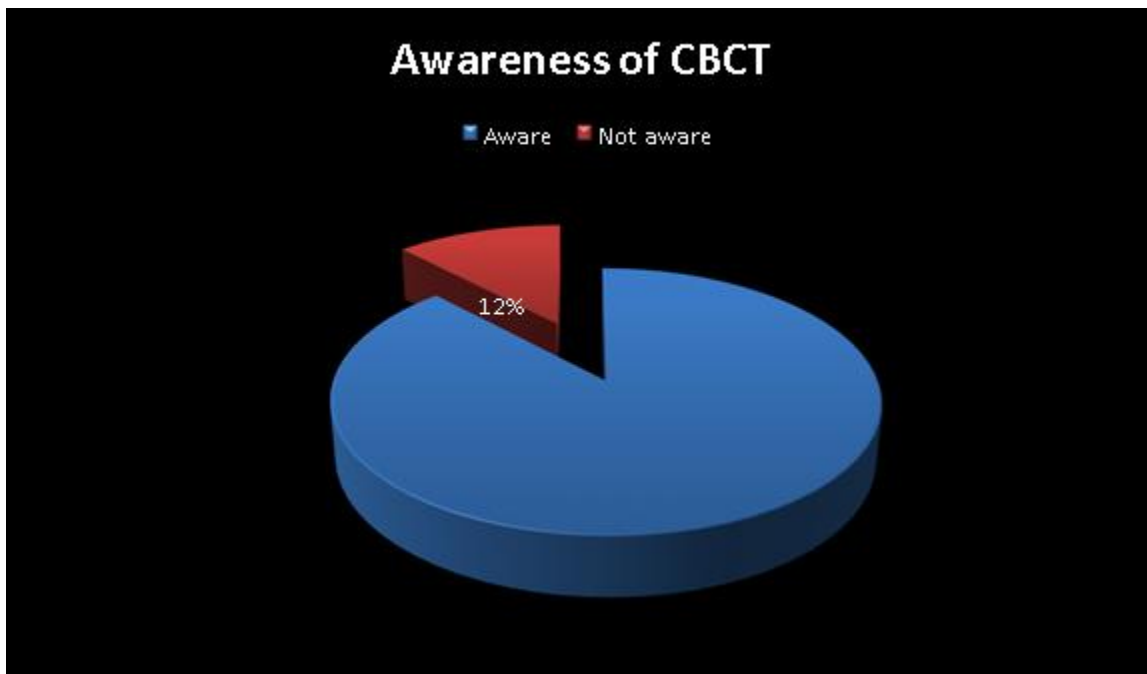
Awareness of CBCT among the study participants
